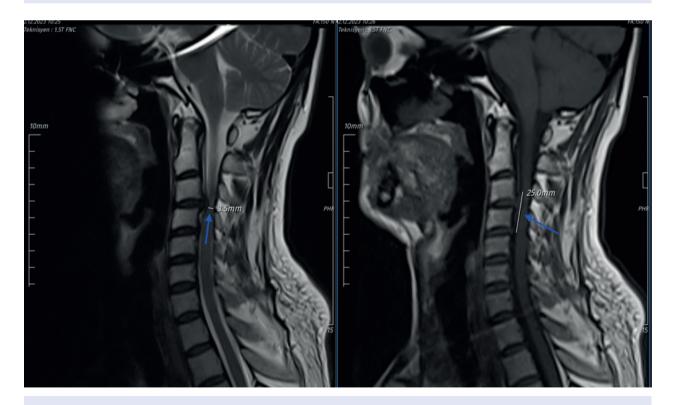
Cervical MRI image (IMLL:25 mm, channel diameter at MSCC level:3.5 mm).
